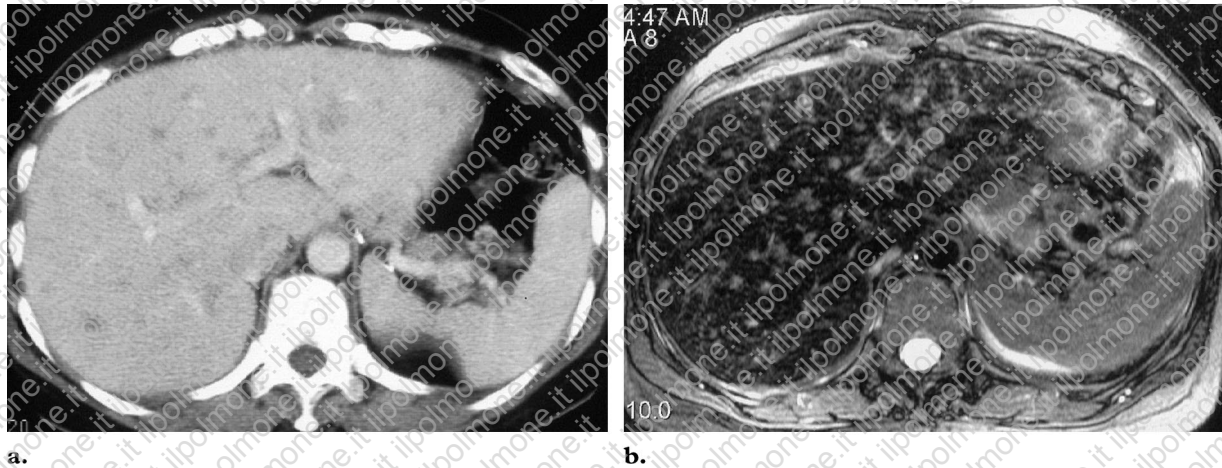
Hepatic involvement in a 49-year-old woman with pulmonary sarcoidosis. (a) Contrast-enhanced abdominal CT scan shows multiple, irregularly shaped nodules of variable size in the liver. (b) T2-weighted MR image obtained after the administration of ferumoxides (Feridex; Advanced Magnetics, Cambridge, Mass) demonstrates multiple small, high-signal-intensity nodules throughout the liver.
